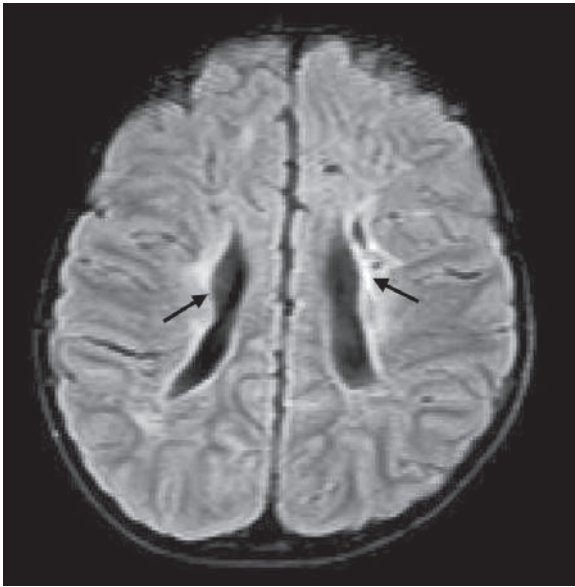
Axial T2 Flair MRI image of brain showing periventricular leukomalacia and periventricular hyperintensities (arrows) in spastic diplegic cerebral palsy
